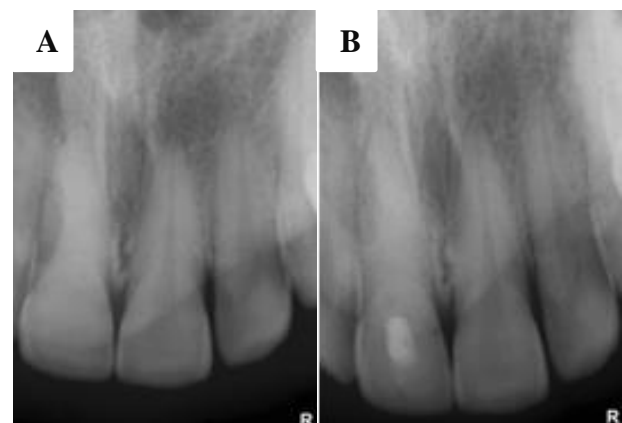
(A and B) Pre and post preapical radiograph.
